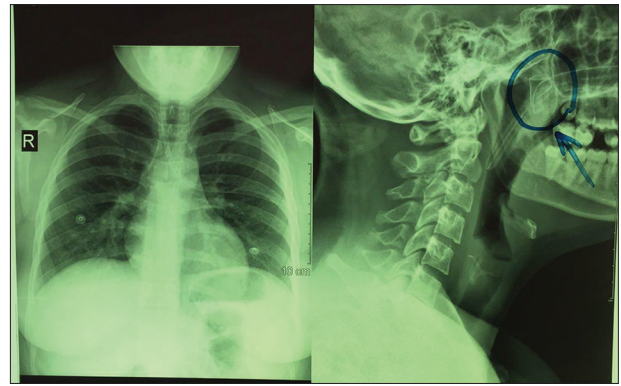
Chest and lateral neck X-ray for detection of NG tube location
